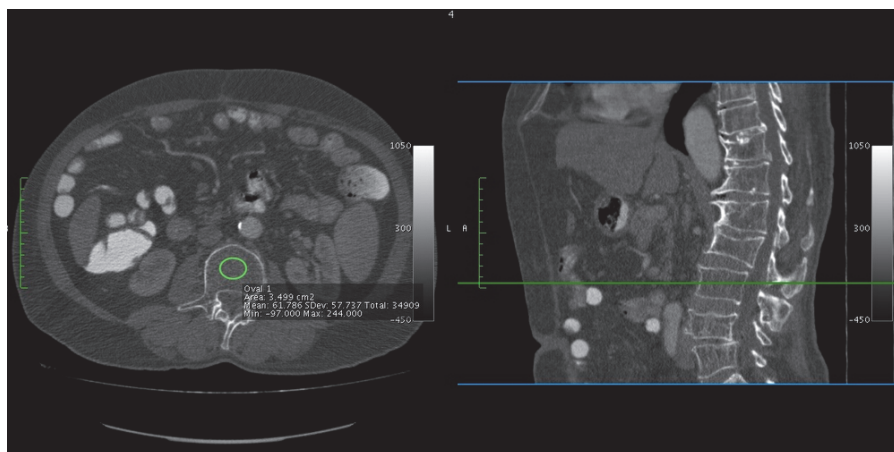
Axial L3 vertebral CT slice of 61-year old man shows osteoporotic L3 vertebral bone density measurement in Hounsfield Unit (mean: 63 HU).
